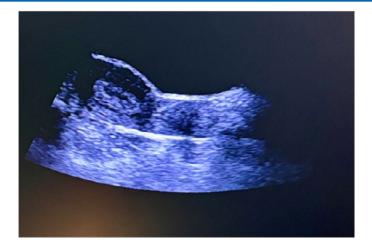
Uterus with Cusco's Speculum in-situ. The Lips of the Speculum are visible as long hyper-echoic line- creating artifacts in Transabdominal Ultrasound image.
